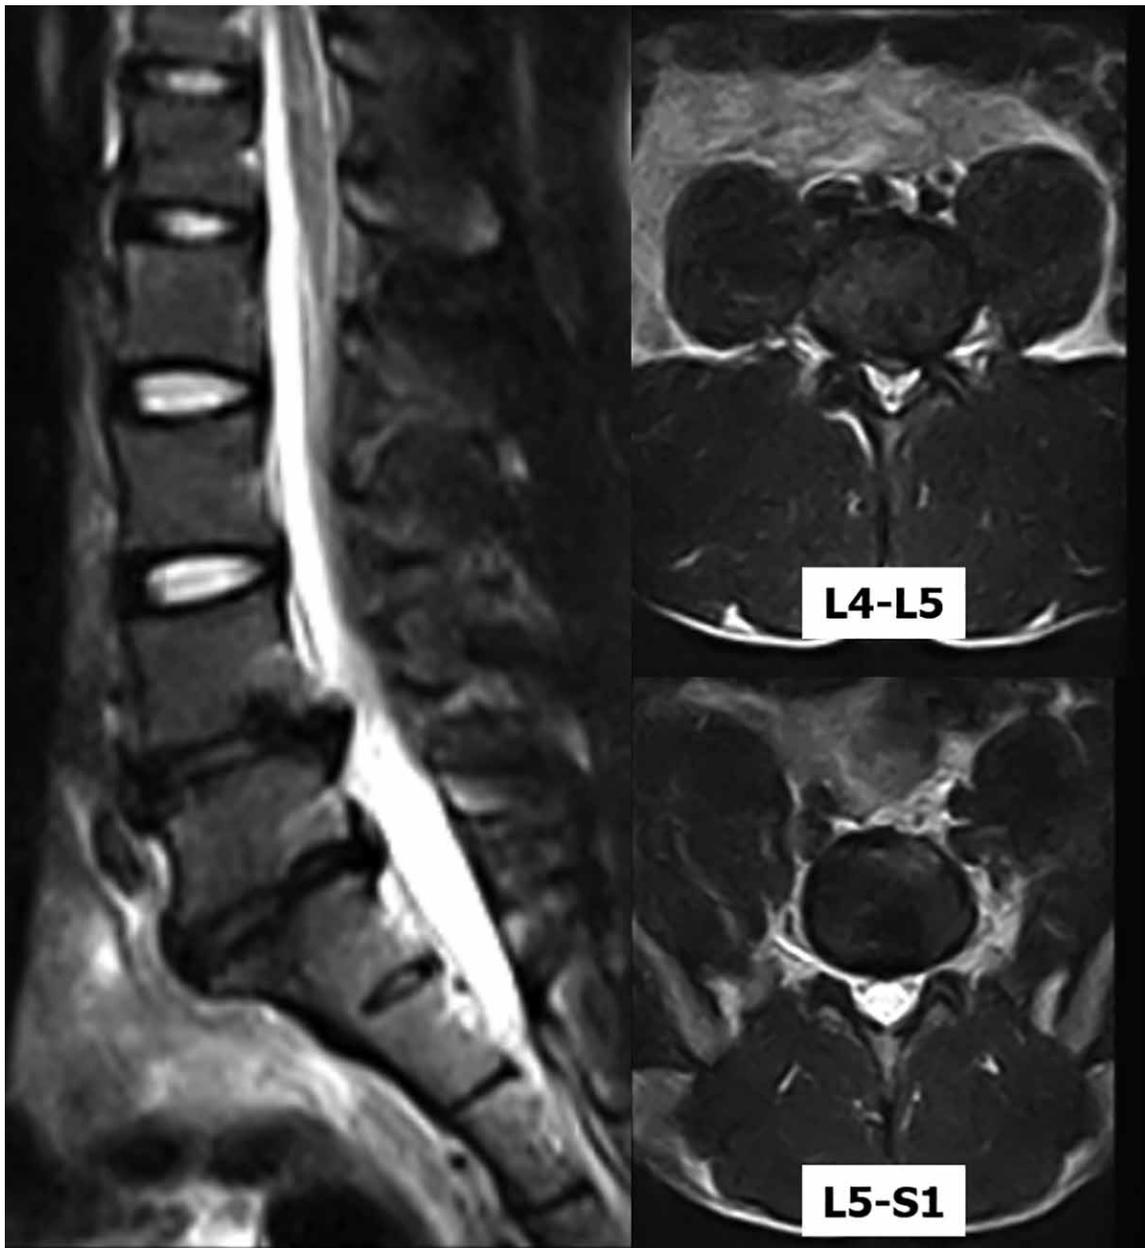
T2 sequence of lumbar MRI revealed the presence of discal pathologies at L4-5 and L5-S1 levels.
